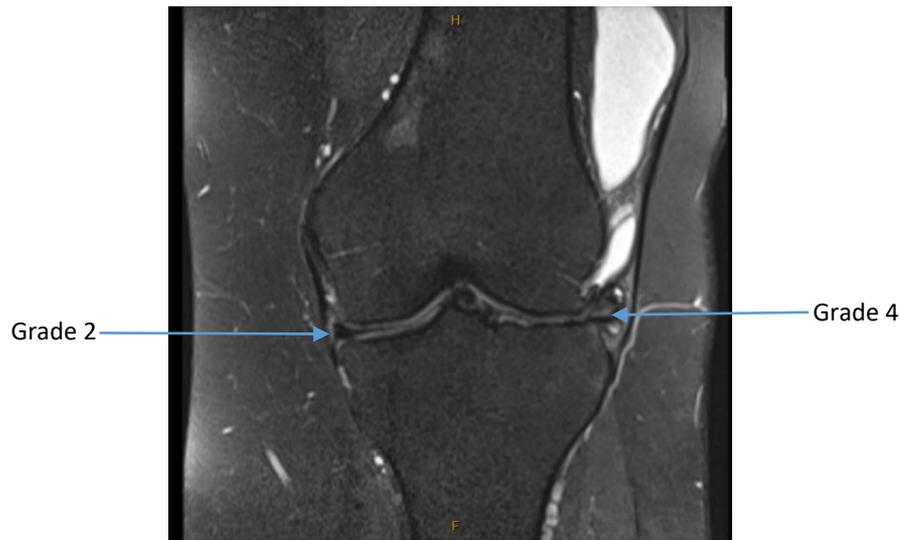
Grade 4 lateral meniscal lesion and Grade 2 medial meniscal lesion on coronal (MRI image of a study participant).
